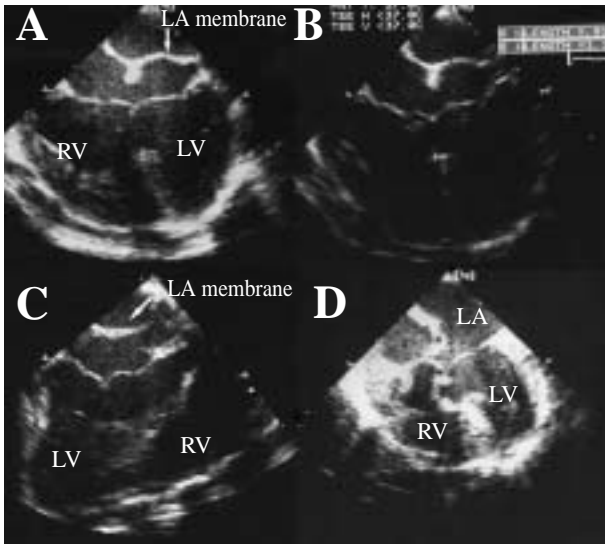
Intra-operative trans-esophageal echocardiography: (A) Preoperative transesophageal echocardiography demonstrated a membranous structure in the left atrium in the four chambers view. (B) Atrio-ventricular defect was also documented by preoperative transesophageal echocardiography. (C) The membranous structure was also evident in the longitudinal two chamber view. (D) Post-operative transesophageal echocardiography proved no residual lesion in the left atrium, atrial septum and ventricular septum (*Asterisks indicate Dacron patch for atrial and ventricular septal reconstruction). White arrows indicate left atrium membrane; LA: left atrium; RA: right atrium; LV: left ventricle; RV: right ventricle.
